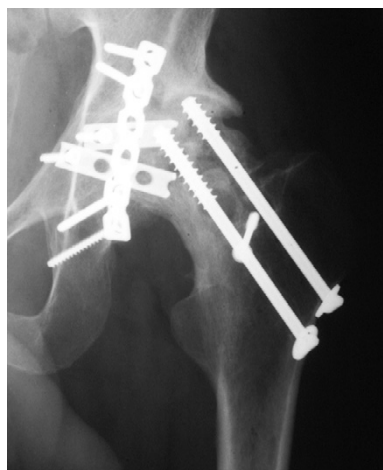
Anterolateral radiograph of the hip 10 months after the trauma, showing a united femoral neck fracture with metal penetration into the joint space. There is collapse of the lateral aspect of the femoral head with extensive sclerosis, indicating severe osteonecrosis.
